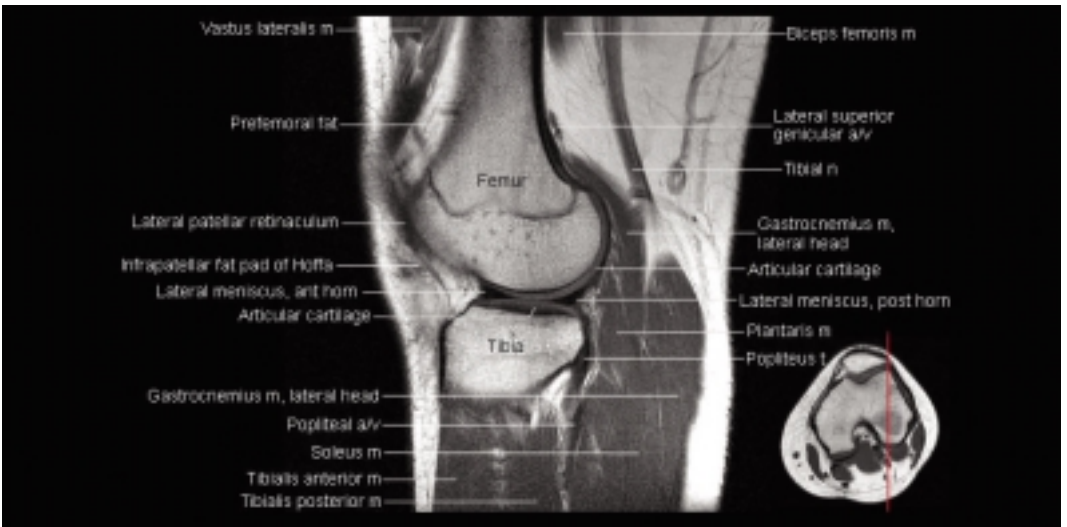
Sagittal MRI image of the knee showing the musculature, blood supply and innervation of the knee
